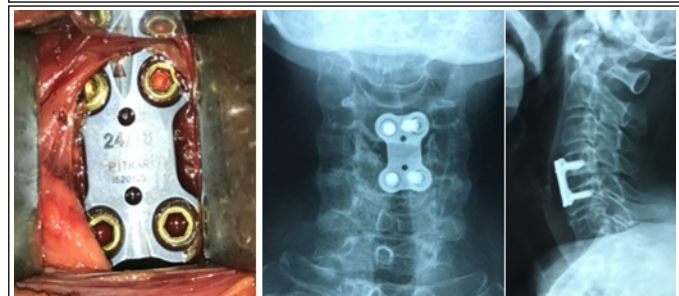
Intraoperative picture with postoperative X-ray showing plate fixation.
